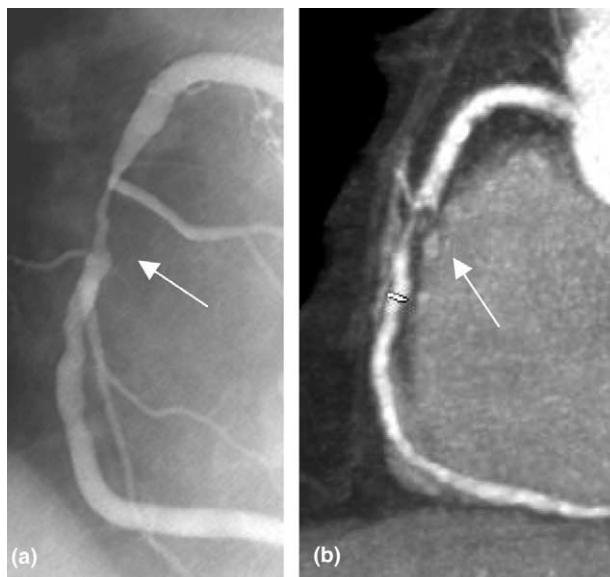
(a) Angiogram (LAO projection) shows the presence of a significant stenosis in the middle part of the RCA. (b) MSCT (MIP) shows significant stenosis in the middle part of the RCA. LAO: left anterior oblique; MIP: maximum intensity projection; MSCT: multislice computed tomography; RCA: right coronary artery.
